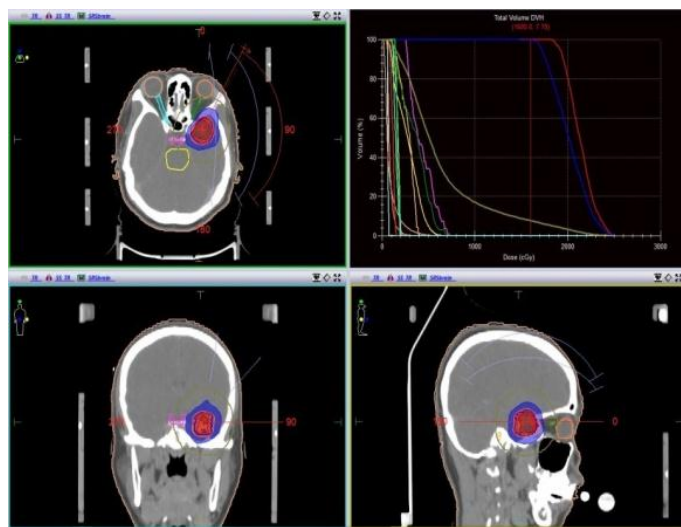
Isodose curve shown on CT images (brain).
